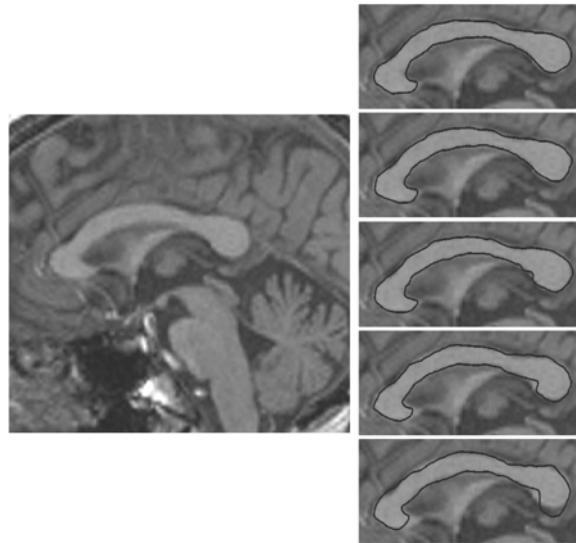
(Left) Midsagittal MR image. (Right) Automated segmentation obtained using the standard ASM trained on 99, 50, 20, 10, and 5 samples (top to bottom, respectively). The standard ASM performs well when enough training samples are available, relative to the variability of the structure, but starts to fail when relatively few training samples are available.
